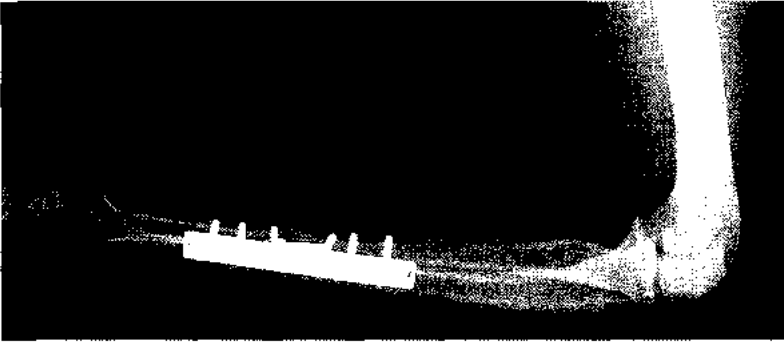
(*left*) Both bones fracture of the forearm treated with open reduction and compression plate fixation as seen on a lateral radiograph. This fixation restores the anatomic axis of the radius and ulna.
